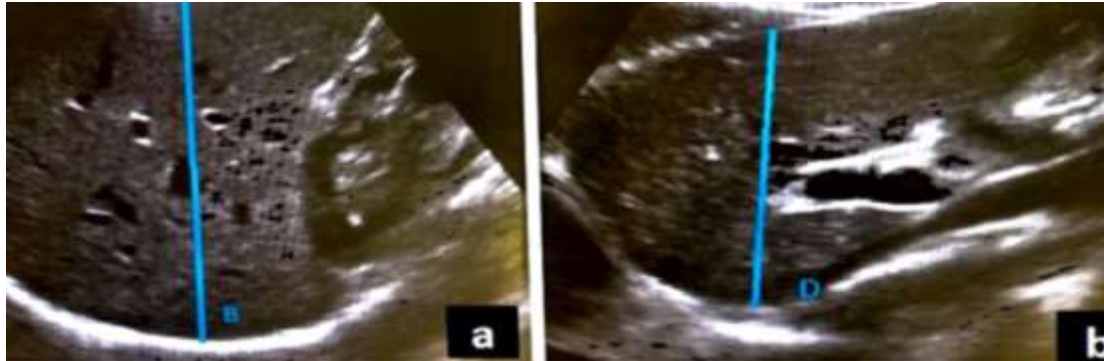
Liver measurement using ultrasound imaging
